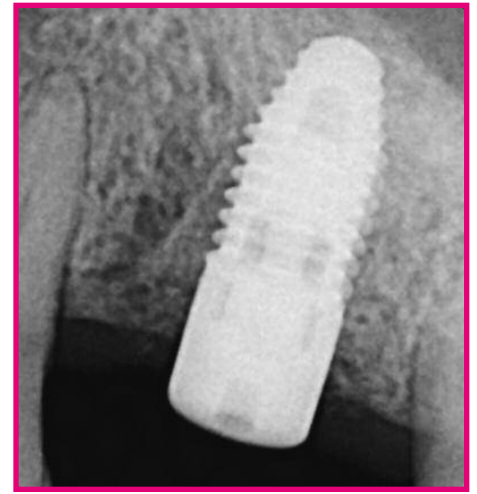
Four months following implant placement and sinus lift, a postoperative radiograph helps to confirm osseointegration.
